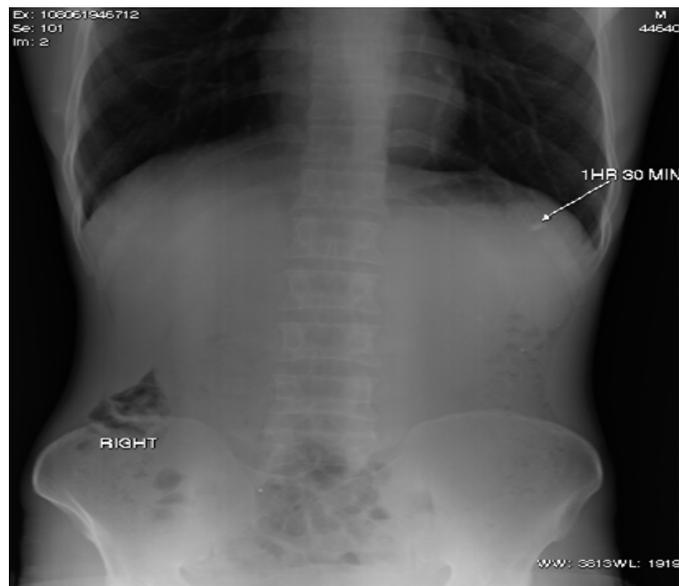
In vivo x-ray studies in fed state.
